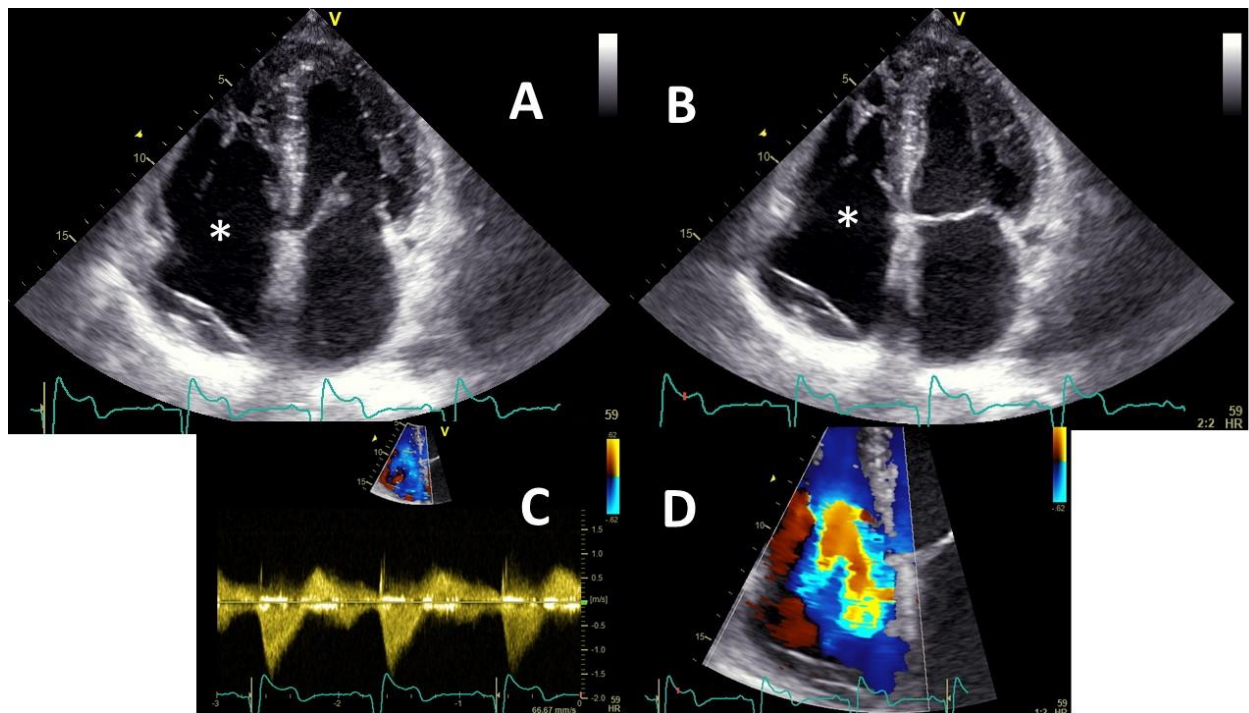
Transthoracic echocardiography (Apical 4 chamber view) showing (A) opened tricuspid (*) and mitral valve during diastole, while in systole (B) mitral valve closes normally but a fixed semi-open position of the tricuspid valve (*) is noticed. (C) Continuous wave signal showing a dense triangular signal and (D) Colour doppler flow through the tricuspid valve, both matching a severe tricuspid regurgitation grade 4/4.
